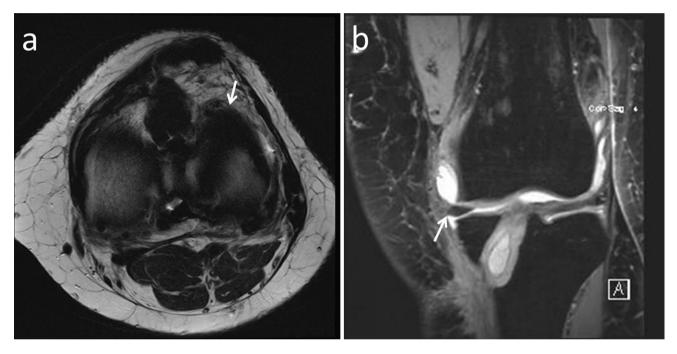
Axial (a) and sagittal (b) MRI showing an extruded medial meniscus anterior horn off the medial tibial plateau (*white arrows*) due to an iatrogenic medial meniscus root avulsion after malpositioned ACL tibial tunnel reaming (left knee)
